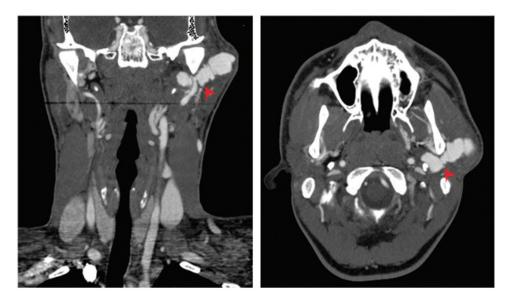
Radiographic evidence of zone III external carotid artery injury. Coronal (left) and axial (right) views of left-sided zone III external carotid artery pseudoaneurysm and perivascular hematoma with active extravasation of blood (red arrows) on CTA.
